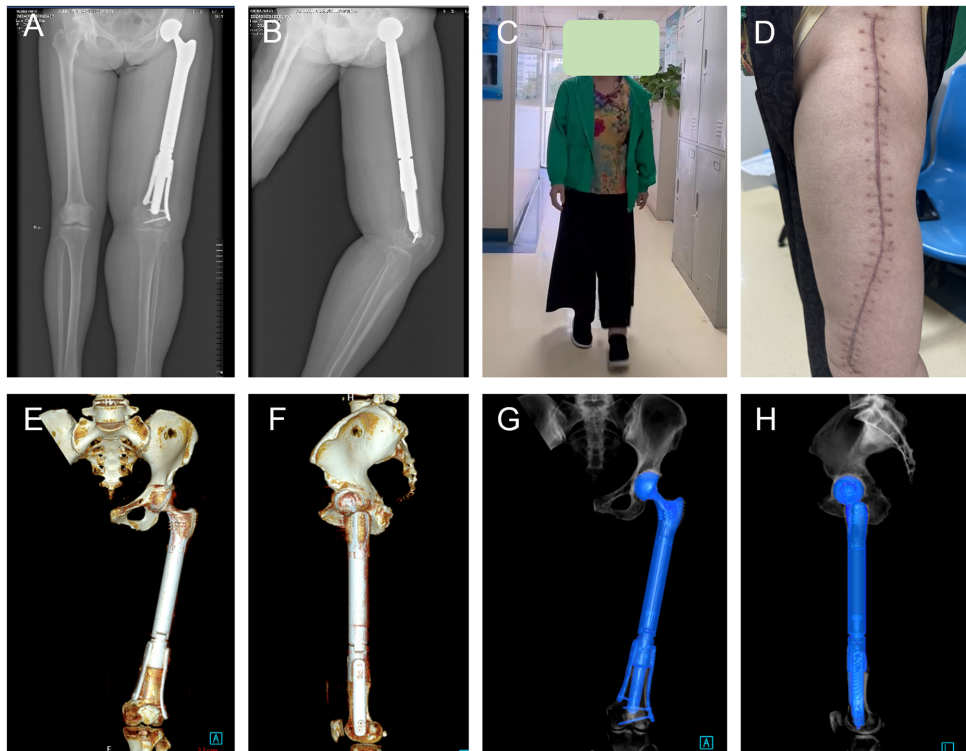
Postoperative imaging and functional outcome after 1 year. (A) Coronal X-ray showing stable prosthesis position without loosening or fracture. (B) Sagittal X-ray demonstrating satisfactory prosthesis alignment and fixation. (C) Clinical photograph of the patient walking independently without assistive devices. (D) Clinical photograph showing well-healed surgical wound at the operative site. (E) Coronal 3D CT reconstruction revealing good prosthesis-residual femur interface fitting, no bone resorption or prosthesis loosening. (F) Sagittal 3D CT reconstruction confirming satisfactory prosthesis position, secure fixation and close contact with the residual femur. (G) Coronal 3D CT with segmented blue-colored prosthesis visualizes satisfactory prosthesis position and stability. (H) Sagittal 3D CT with segmented blue-colored prosthesis visualizes secure fixation of the implant.
